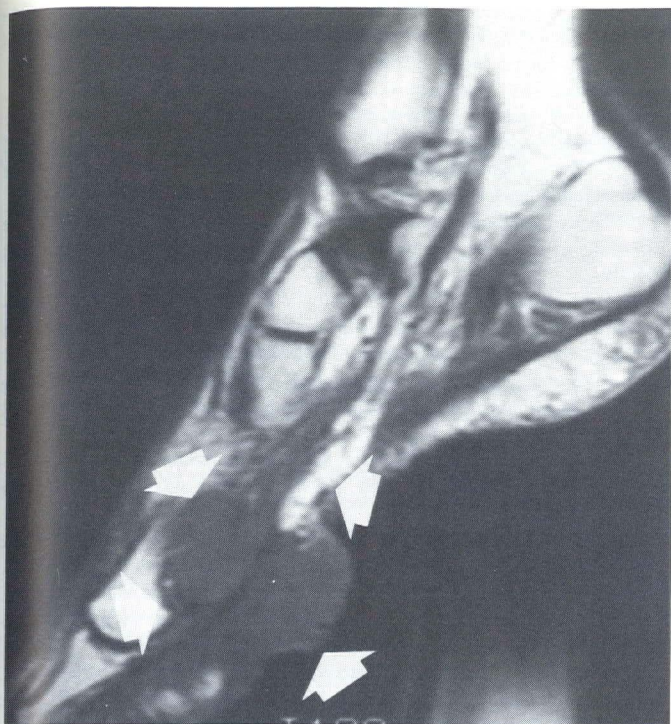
Synovial sarcoma of the foot. Bulky, fungating lesion evident. The predominant value of MRI in this instance was determining a level for amputation. Note excellent display of tumor margins (arrows).
